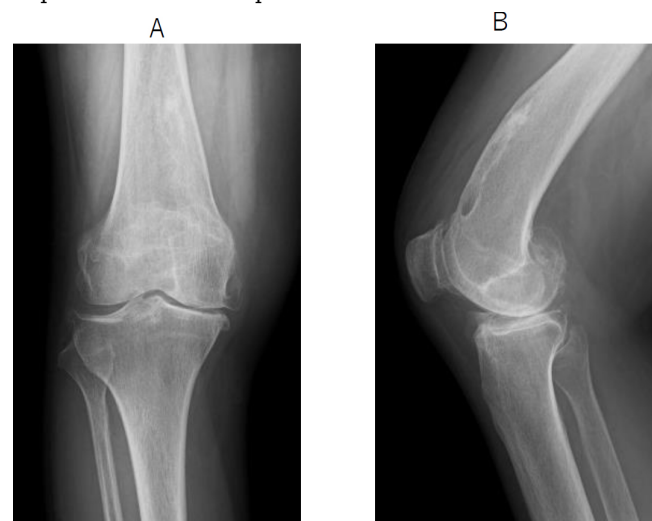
Preoperative radiograph of the right knee.
